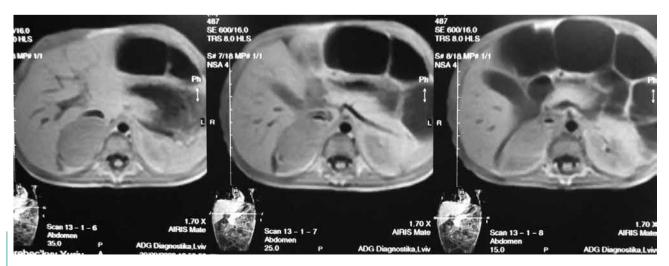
MRI of the patient's abdomen showing a sub-diaphragm paravertebral tumour
